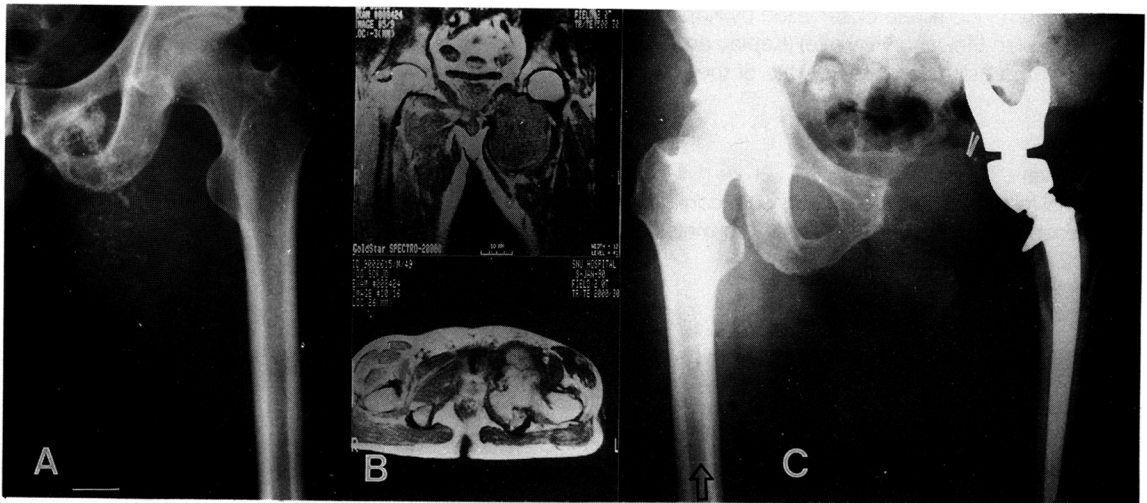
A 49-year-old patient with IIB chondrosarcoma of the pubis (A). Adductors and flexors of the hip were invaded significantly in magnetic resonance image (B). Though the function of this patient was fair, his limb was saved with a wide resection and reconstruction using a custom-made prosthesis (C). (Case No.18)
